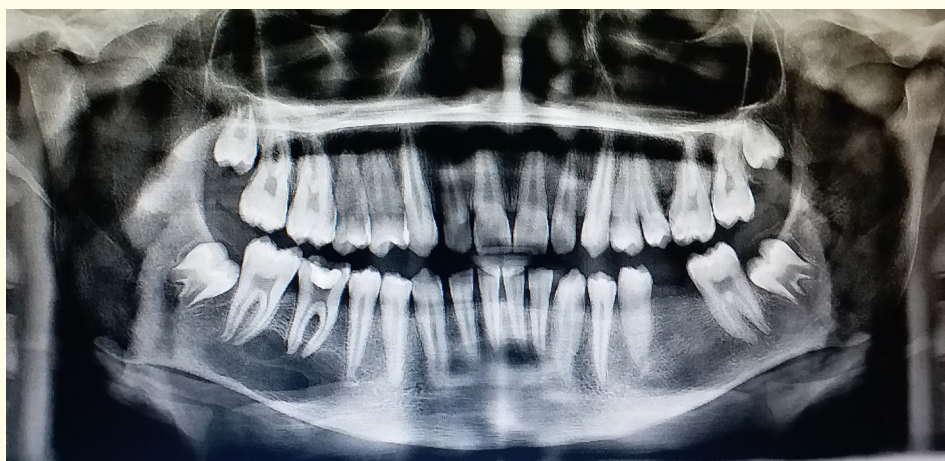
Orthopantomograph findings
